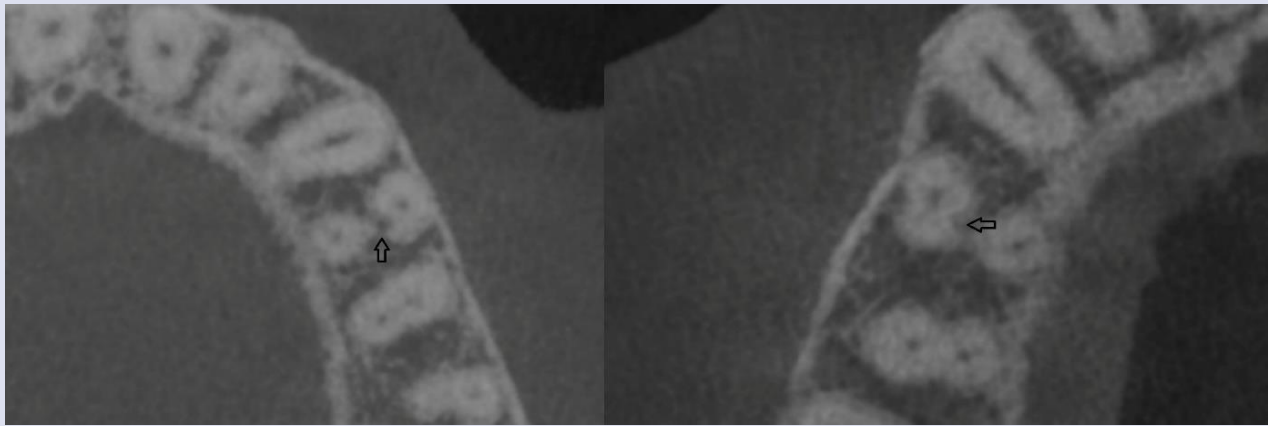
CBCT images of radicular grooves (black arrows) on axial sections.
